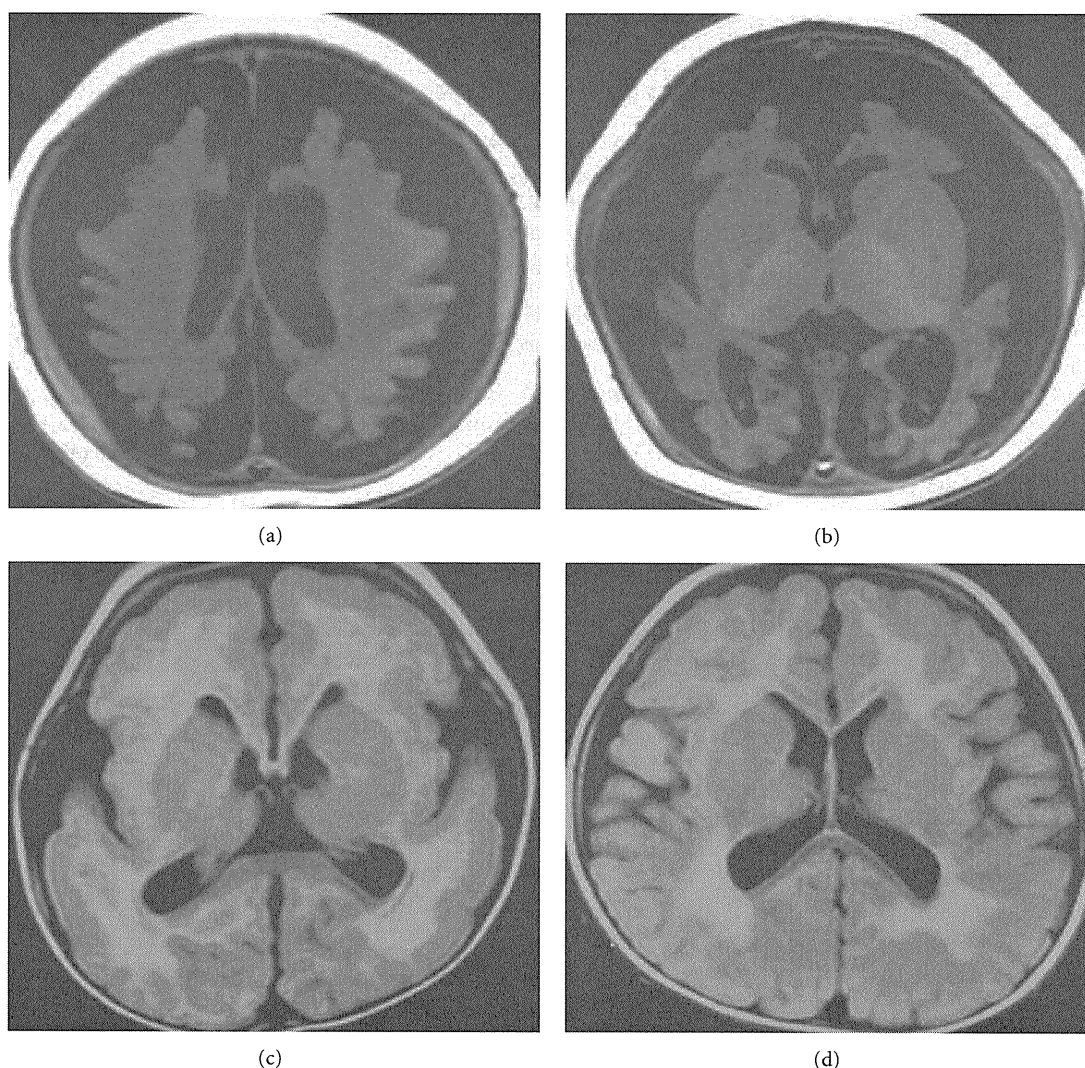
Representative MRI findings in different malformations of cortical development (MCD). Figures 4(a) and 4(b) showed severe cortex dysplasia in bilateral parietal lobes and frontal, temporal and occipital lobes, respectively, in the telencephalon of a 5-month-old male with NDD. Figure 4(c) demonstrated typical lissencephaly in a 9-month-old female with Miller-Dieker syndrome. The white matter volume was decreased while the cortex was thick and smooth due to lack of enough sulcation, forming the so-called pachygyria malformation, and the thickened and irregular cortex in Figure 4(d) revealed the cobblestone cortical malformation in a patient with muscle-eye-brain disease.
